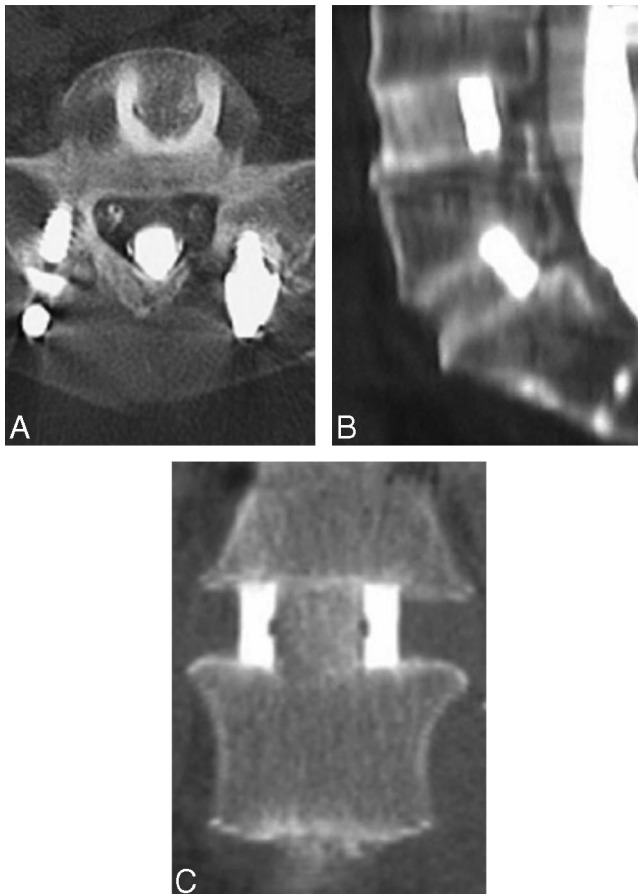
Supplemented with posterior instrumentation, FRAs without any ICBG or BMP have a radiographic fusion rate of more than 90% in more than 100 patients who served as controls for a total disc arthroplasty clinical trial at our institute (A–C). Twelve-month follow-up CTs are shown.
